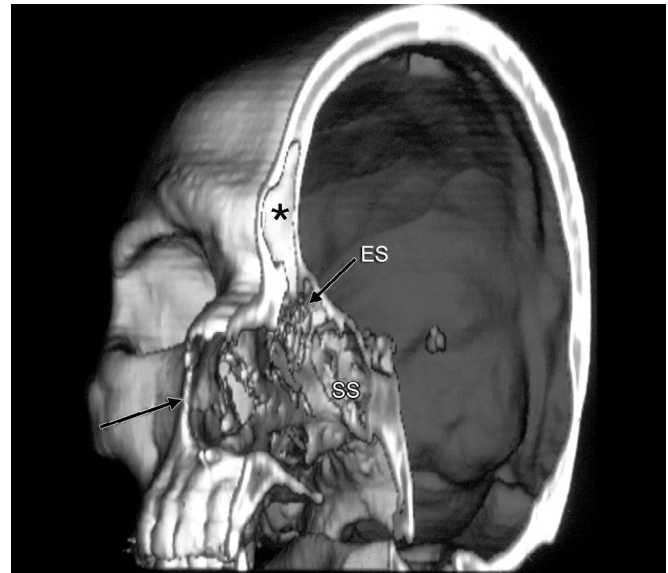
A 3-D computed tomography reconstruction of the same individual in Figure 2.5 shown in oblique parasagittal view where ethmoid (ES) and sphenoid air sinuses (SS) can be viewed. The black asterisk indicates the frontal sinus and the black arrow is pointing to the piriform aperture rim where, just posterior to it, is the site of attachment of the inferior turbinate.
